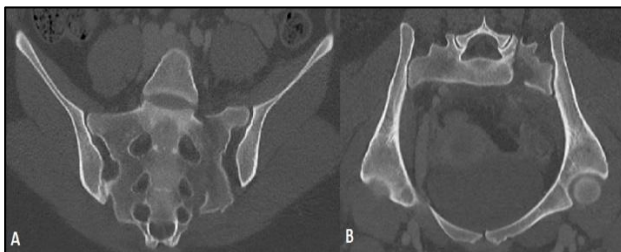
(A) Coronal; (B) axial computed tomography (CT) images of the pelvis demonstrating a vertical sacral fracture lateral to the neural foramina, consistent with a Denis zone 1 classification.
